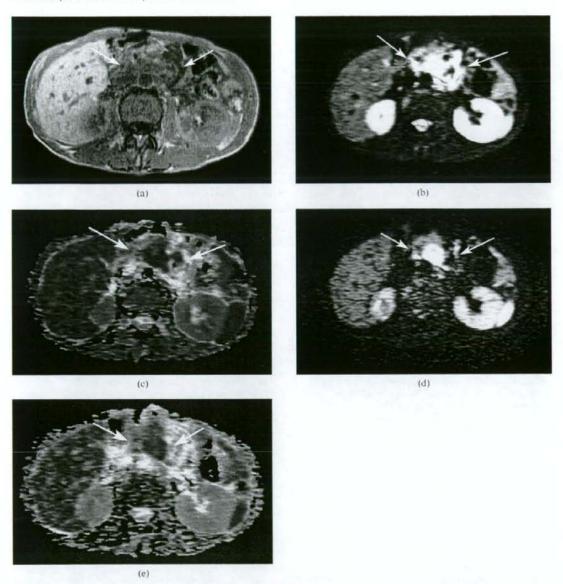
Images from a 65-year-old man with advanced pancreatic cancer who showed early progression. Progression was noted on the 2-month follow-up CT. (a) Transverse T_1 weighted fast-field echo image shows an irregularly shaped tumour at the pancreatic head (arrows). (b,c) Isotropic diffusion-weighted image (b) and the apparent diffusion coefficient (ADC) map (c) using the middle b-value (400 s mm⁻²) show an inhomogeneous high-signal mass (arrows). The ADC was 0.98×10^{-3} mm² s⁻¹. (d) Isotropic diffusion-weighted image and (e) ADC map with a high b-value (1000 s mm⁻²) show an inhomogeneous high-signal mass (arrows). The ADC was 0.84×10^{-3} mm² s⁻¹.
